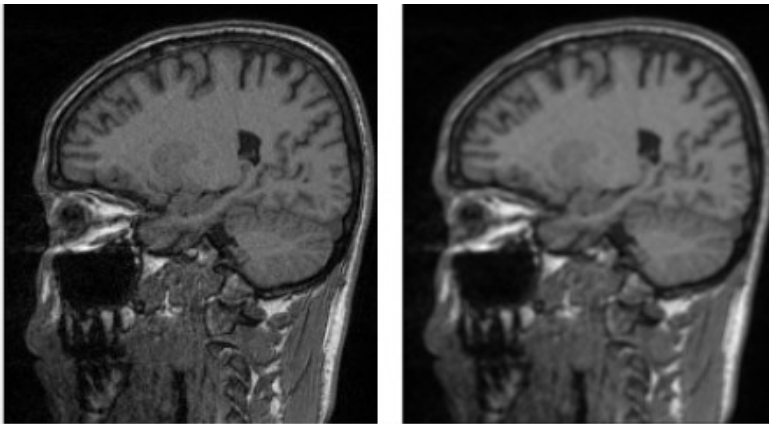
Image pre-processing follows an average filter process to smooth 2D MRI images with noise in order to construct 3D image. The equation below describes elimination of noise by applying the average filter that is convoluted with each 2D MRI image.
